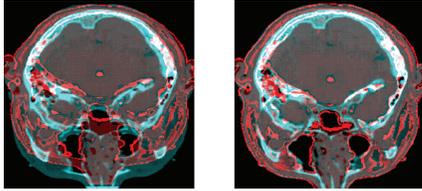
CT (cyan) and transformed MRI (red). (a) unregistered, (b) registered. White regions indicate matched bone regions expressed similarly in the CT and the transformed MRI scan.
